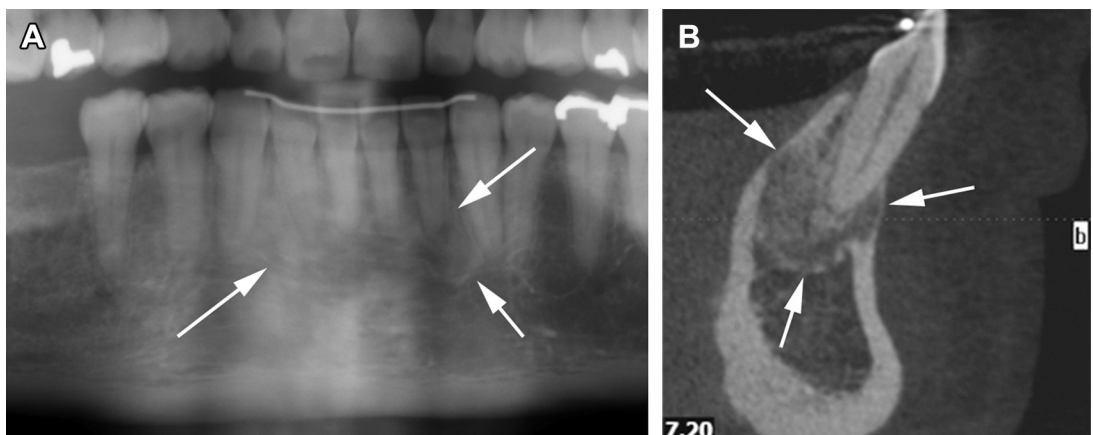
(A) Cropped panoramic radiograph of a 40-year-old African American female patient shows mixed density lesions (arrows) in the periapical region of the anterior mandibular teeth consistent with periapical osseous dysplasia, stage III. The lesions are difficult to visualize because of superimposition of the blurred spine image over the anterior jaws. (B) Sagittal cone-beam computed tomography sections of the mandibular anterior region demonstrate mixed density lesions (arrows) with preservation of peripheral lucent rims of variable thickness and definition. Portions of the buccal and lingual cortical plates are thinned. A secondarily infected lesion may demonstrate increased width and definition of the peripheral lucent band, but not to the extent of secondary idiopathic or simple bone cavity formation. In this case, cross-sectional imaging greatly aids visualization of the lesions and subsequent diagnosis.
